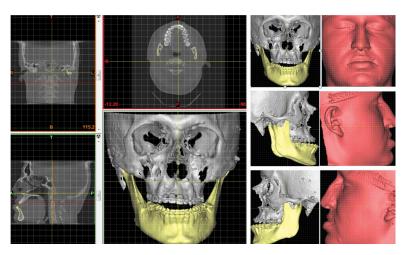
Initial segmentation of patient CT scan data showing hard and soft tissues reconstructions.
